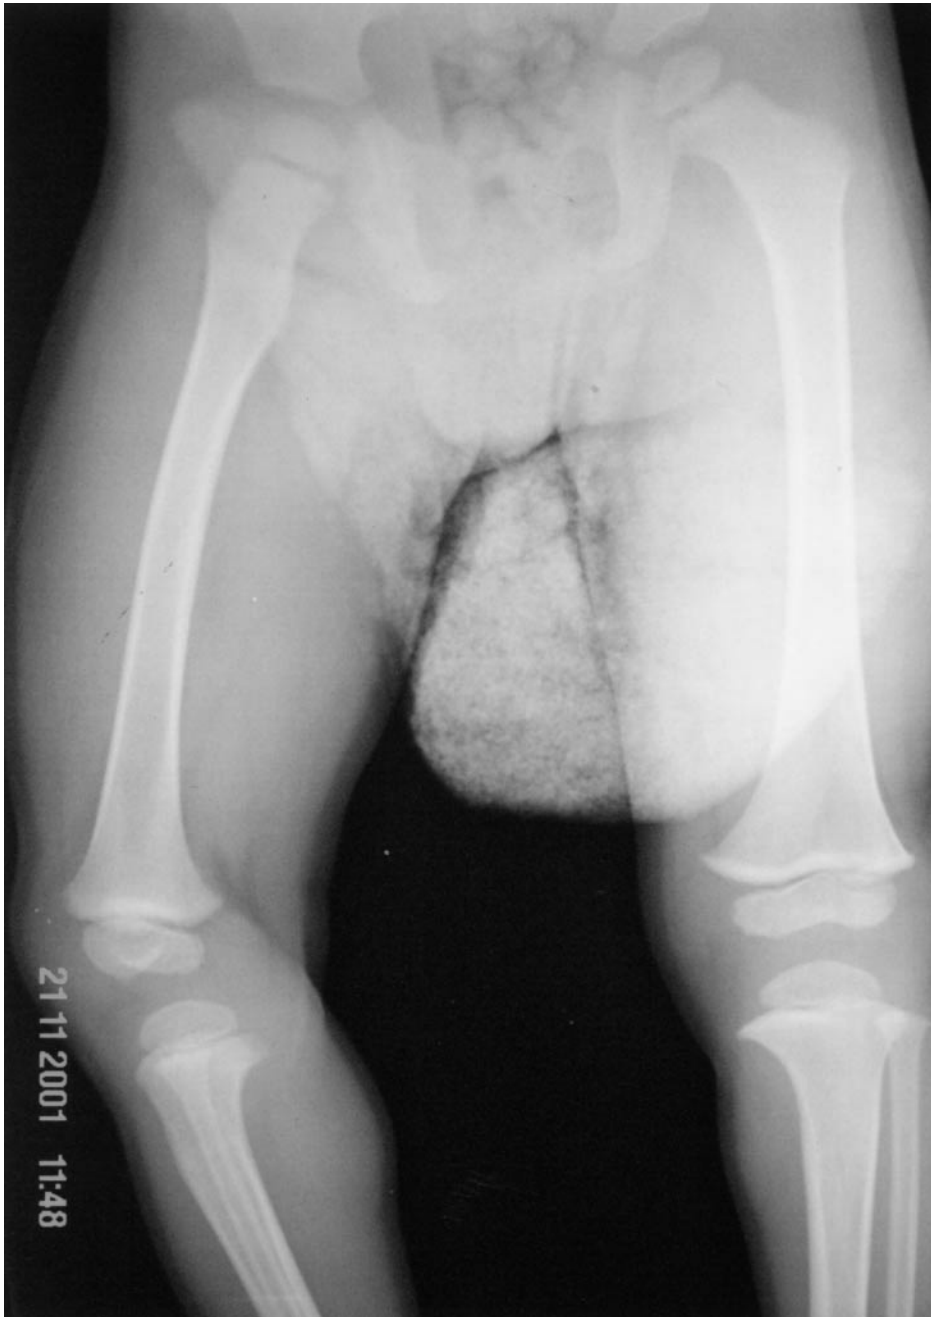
Long-bone radiograph demonstrating lead line at distal left femur of patient 1.
